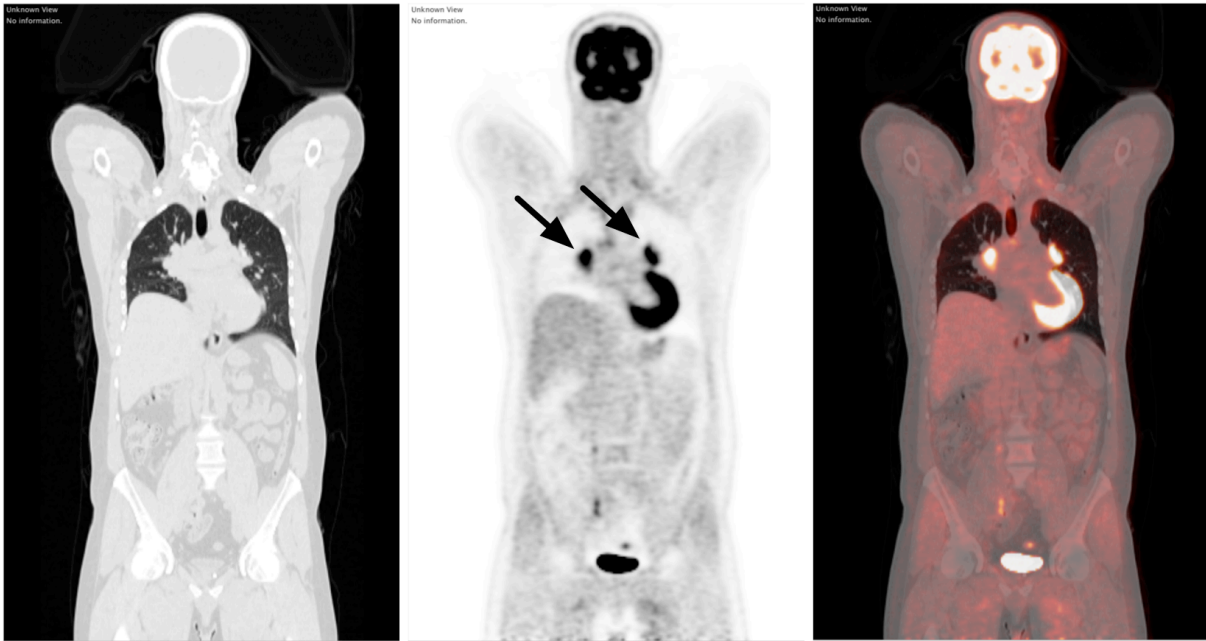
A PET-CT image of a patient diagnosed with lung cancer. The functional PET image (middle) clearly depicts the increased glucose evident in the lungs and its surrounding structures (indicated by arrows). The anatomical CT image (left) provides the sharp boundary of the surrounding structures. The fusion of the two images (right) shows the combined functional and anatomical information. The lookup tables (LUTs) used in the CT, PET and fusion images are grayscale, inverted grayscale and ‘red hues on white’ for PET fused with grayscale for CT, respectively.
